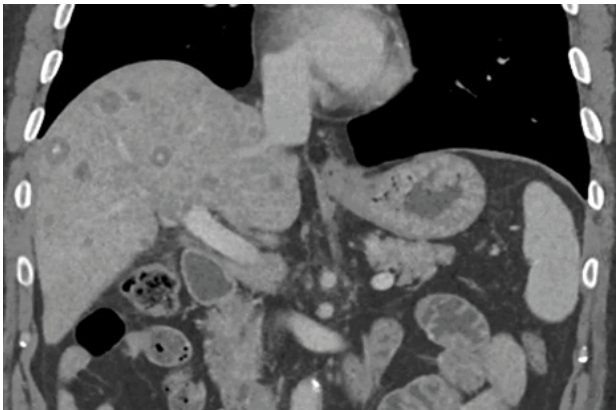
Follow up CT scan on September 28th, 2025, following first radioembolization intervention- showing multiple hepatic lesions that are stable in size with a decrease in rim-enhancement and development of central calcification in some lesions.
